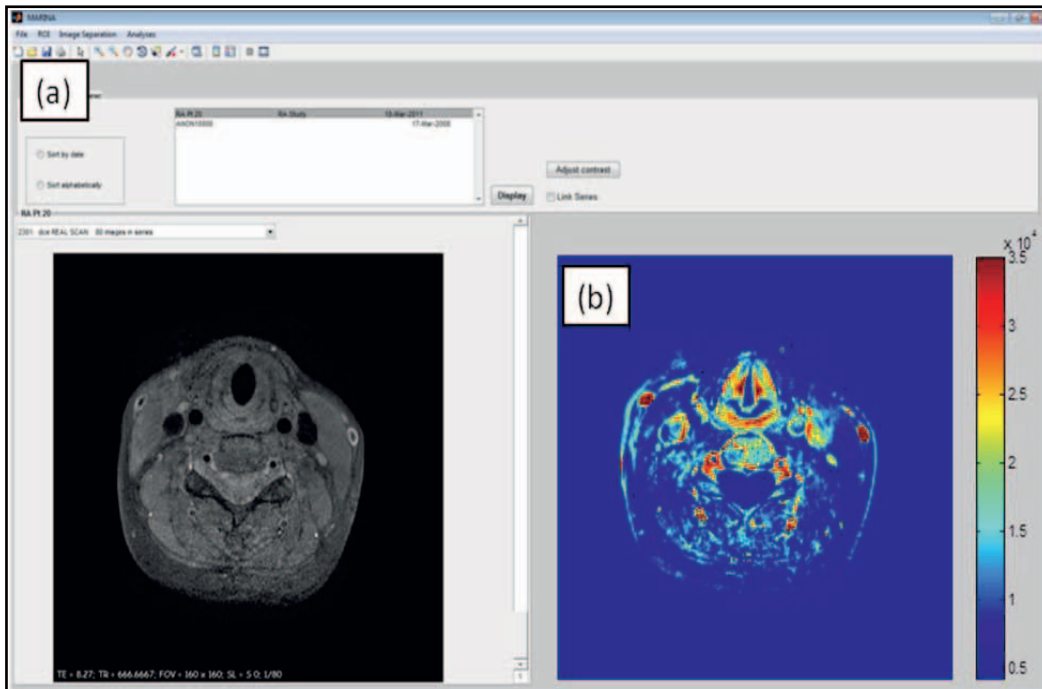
(a) Main user interface window of MARINA showing DCE-MR image from human carotid study overlaid with (b) the AUC map of the DCE-MRI data.
